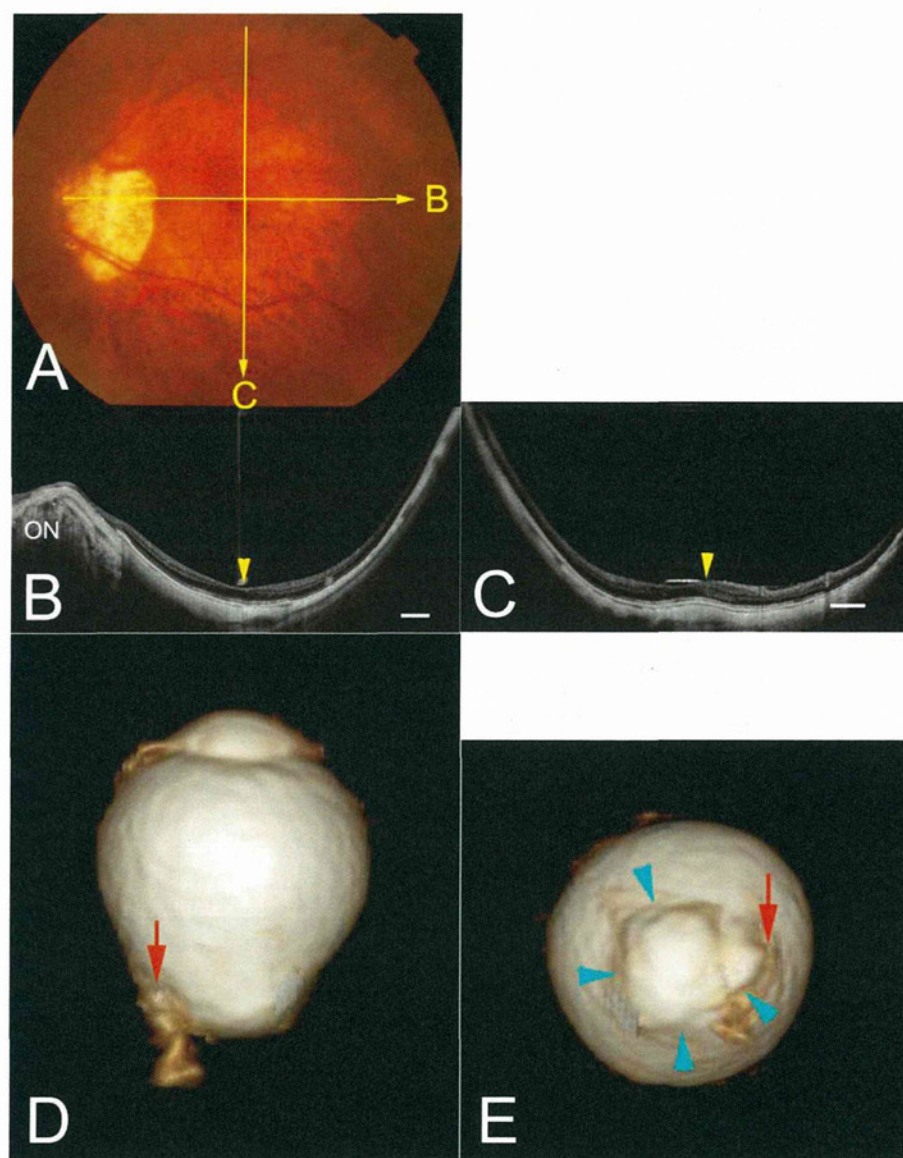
Relationship between highly myopic eyes with the scleral curvature sloped toward the optic nerve by OCT and nasally distorted eye by 3D MRI. (A) Left fundus of a 71-year-old woman with myopic refractive error of −9.5 diopters and an axial length of 26.6 mm. The fundus photograph shows a ring conus around the optic disc and mild chorioretinal atrophy in the macula. Yellow line shows a scanned line by OCT in (B). (B) Image from a horizontal OCT scan shows that the retinal pigment epithelium (RPE) and the curvature of the inner scleral surface are almost straight and are sloped toward the optic nerve (ON). Scale bar = 1 mm. (C) Inferior view of a 3D MRI image of the eye shows that the globe is elongated slightly nasally and that the optic nerve (arrow) is attached at the most protruded part of the globe. (D) Posterior view of 3D MRI image of the eye shows that the optic nerve (arrow) is attached at the center of the protrusion of the globe.
